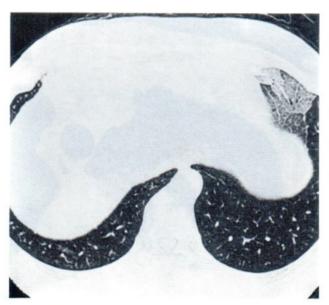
Pulmonary hemorrhage. HRCT chest of a 46-year-old woman, who presented with cough and blood-tinged sputum for 3-4 days and had spontaneous improvement without any treatment, demonstrated a small area of crazy-paving pattern at the anteromedial basal segment of LLL. Two bronchoscopic studies showed an organized hematoma at the basal segment of LLL bronchus which rapidly dissappeared in 1 wk. and nearby dilated bronchial vessels.
